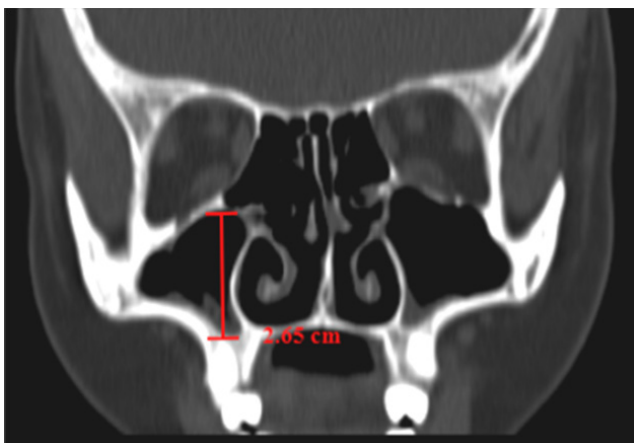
Coronal CT scan showing the measurement of the superoinferior (SI) dimension
